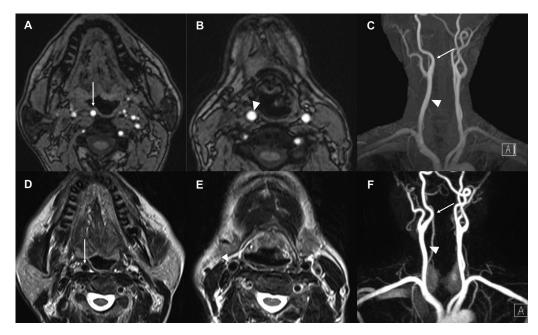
Most recent MR study (4 y after the first MR study). Original 3D TOF MRA images at the level of suprahyoid bone (A), at the level of hyoid bone (B), and 3D TOF MRA MIP images (C), which were taken at the beginning of MR study, showed that the right internal carotid artery (arrow) and the right common carotid artery (arrowhead) were displaced medially. T2-weighted axial image at the level of the suprahyoid bone taken 6 minutes after the first sequence, showed that the right internal carotid artery (arrow) remained unchanged, whereas T2-weighted axial image at the level of the hyoid bone (E) showed that the right common carotid artery (arrowhead) had moved laterally to its normal position. In the MR-DSA MIP image (F) taken 20 min after the first sequence, the right internal carotid artery (arrow) is located medially and the right common carotid artery (arrowhead) is located laterally, which coincide with the findings of T2-weighted images (D, E).
